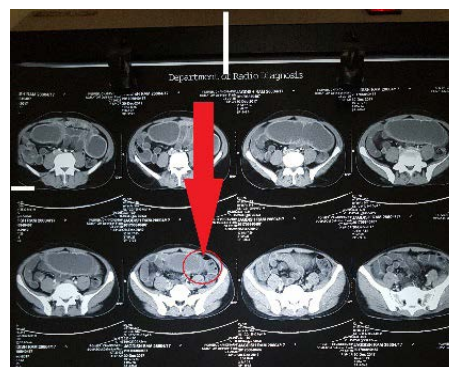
CT scan image showing stricture site (red arrow and circle).
